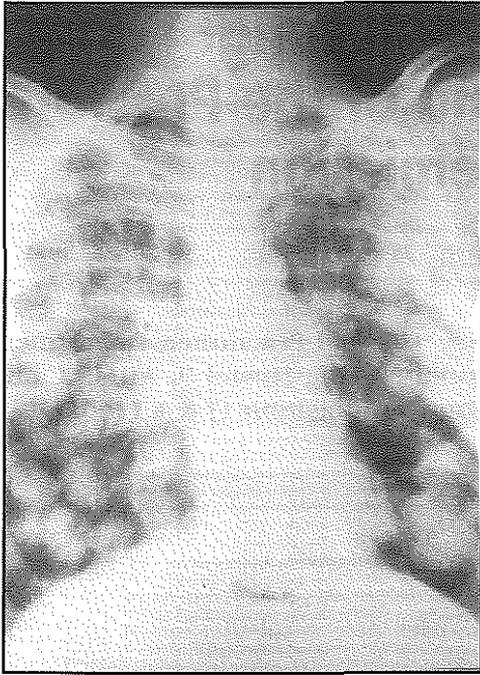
Chest x-ray showing multiple bilateral cannon ball metastases.
